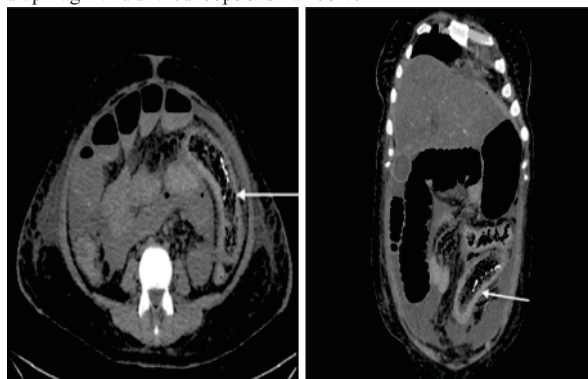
Axial and coronal sections of CT scan abdomen revealed dilated jejunal and proximal ileal loops with an elongated
